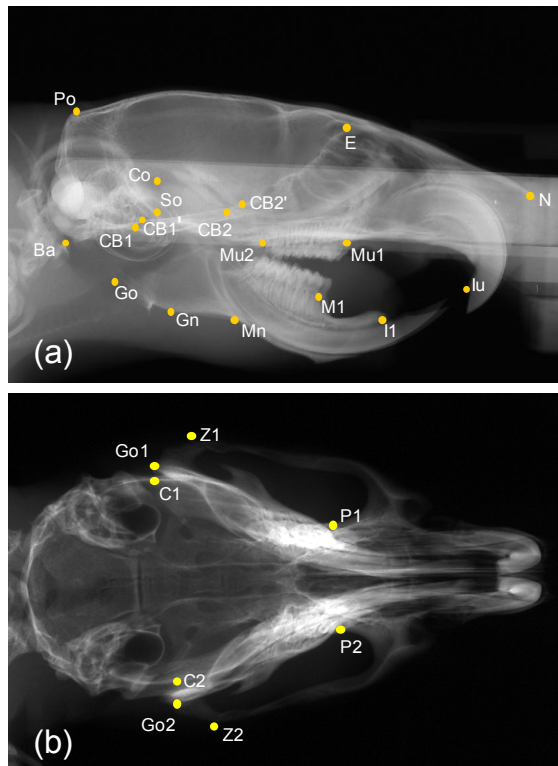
Location of cephalometric points on radiographs: (A) Sagittal and (B) transverse.
